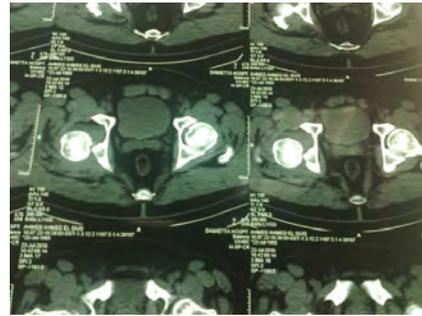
pre op. CT. showing posterior wall fracture of the acetabulum with posterior subluxation of femoral head.
